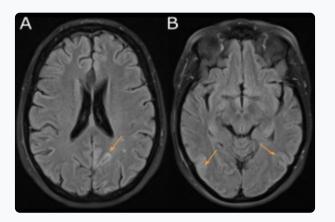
Cortical oedema with enlargement and FLAIR hyperintensity of the cortex (orrange arrows) of the occipital and temporal lobes.
